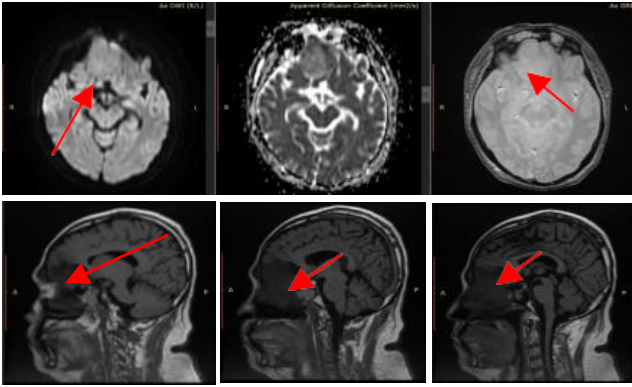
Preoperative axial and sagittal brain MRI sequence with contrast on September 22, 2022
